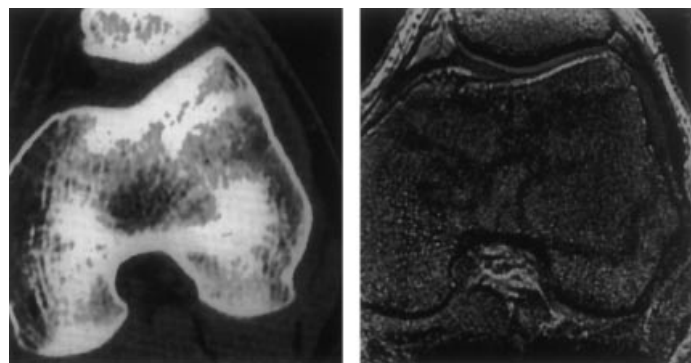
Different types of information provided by X-ray CT and high resolution MRI of the human knee (right—courtesy of S. Majumdar, University of California, San Francisco). The difference in magnetic susceptibility between trabeculae of bone and marrow allows high resolution and high contrast imaging.
